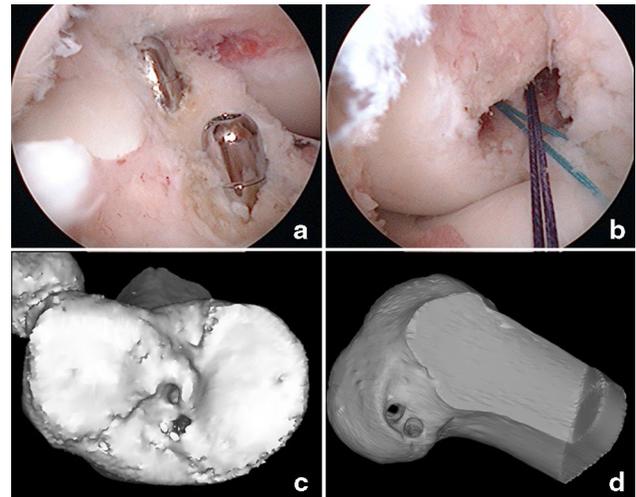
Anatomic double-bundle ACL reconstruction in a right knee. a The tibial AM tunnel is located in the native tibial AM bundle insertion site and the tibial PL tunnel in the native tibial PL bundle insertion site (arthroscopic view). b The femoral AM tunnel is located in the native femoral AM bundle insertion site and the femoral PL tunnel in the native femoral PL bundle insertion site (arthroscopic view). c and d Tibial and femoral tunnel positions on corresponding 3D CT scan
